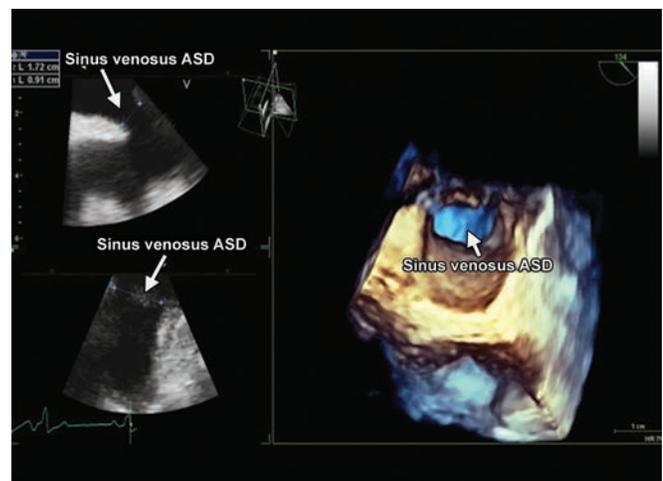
Arrow shows the defect in two- and three-dimensional echocardiography.
